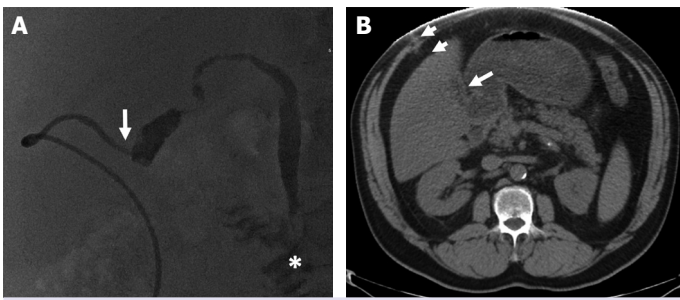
T Removal of cholecystostomy catheter after tract maturation. At 6 weeks, (A) contrast agent does not leak out and passes into the duodenum (*). Two months later, computed tomography (B) shows a heterogeneous sequela of the catheter tract (short arrows) and normal shrunken gallbladder (long arrow).
